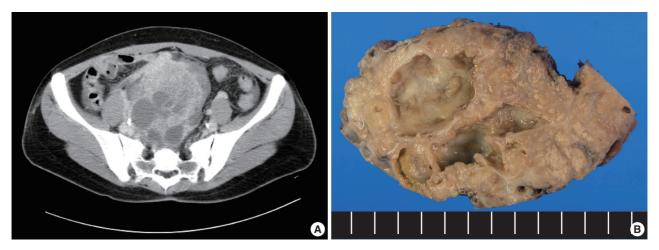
Pelvic computed tomography shows a huge multiloculated mass in pelvic cavity (A). The cut sections of the right ovary disclose solid and multi-cystic mass, measuring  $15 \times 10 \times 7$  cm in size (B).
